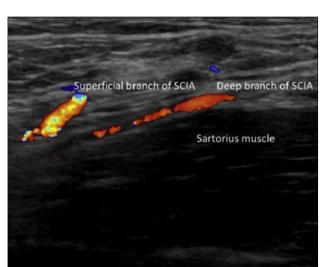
Color Doppler visualizing the superficial and deep branches of the SCIA along with the sartorius muscle. (Source: He Y, Jin S, Tian Z, Fang Z, Ma C, Tao X, et al., Superficial circumflex iliac artery perforator flap's imaging, anatomy et clinical applications in oral maxillo-facial reconstruction. J Cranio-Maxillo-fac Surg Off Publ Eur Assoc Cranio-Maxillo-fac Surg. Mars 2016).
